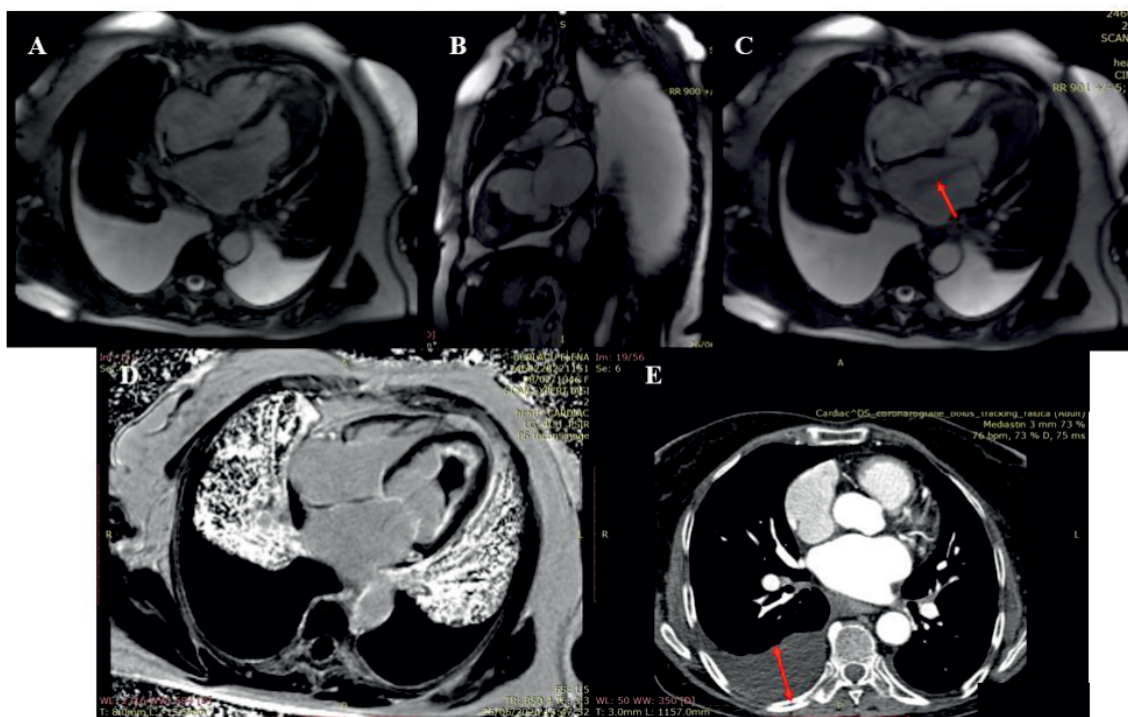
Cardiac magnetic resonance: A, B. Left ventricular apical obliteration with mural thrombus. C. Moderate mitral regurgitation. D. Diffuse circumferential subendocardial LGE, Thrombotic lesion shows no contrast enhancement. E. Torax computed tomography-right pleural effusion.
